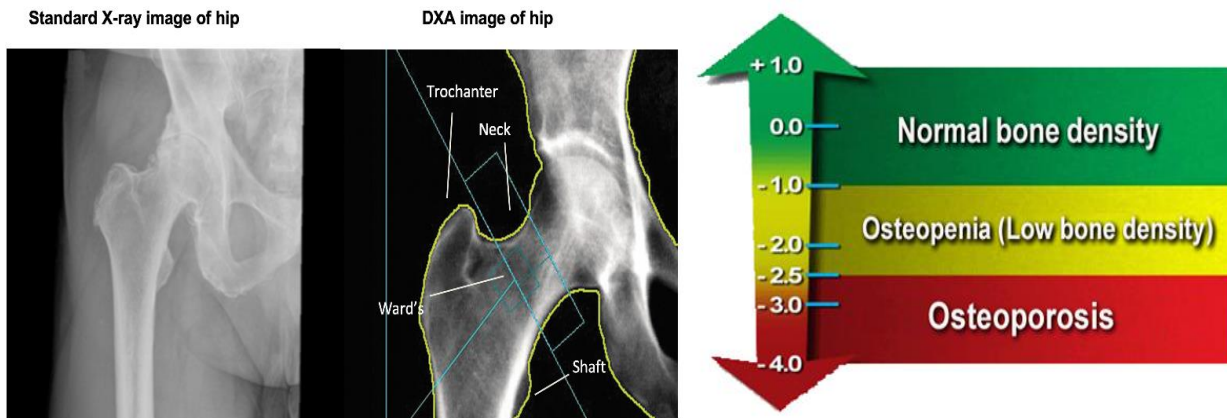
X-ray and DEXA Scan.
